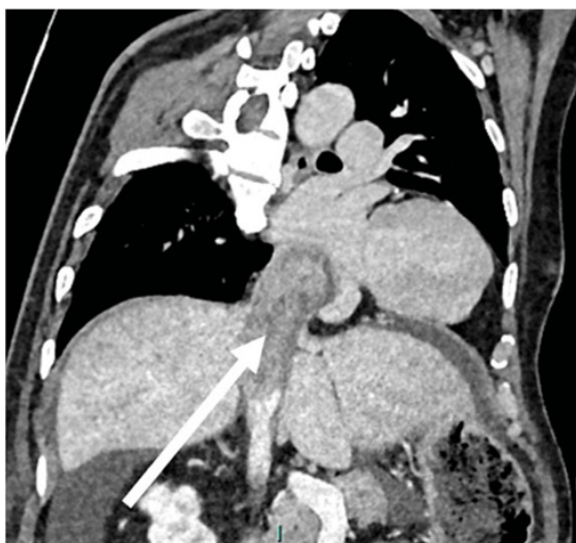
CT chest, abdomen and pelvis with contrast demonstrating a 10cm heterogeneously enhancing solid mass (white arrow) in the right atrium extending into the suprahepatic IVC.
